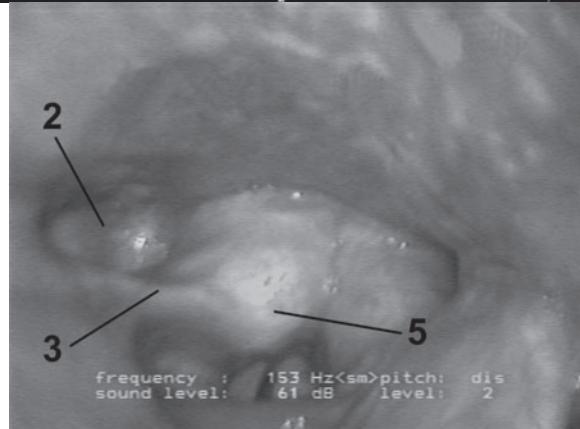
Deepening of the piriform recess (2), thickening and medialization of the aryepiglottic fold (3) and anterior positioning of the arytenoid cartilage (5) in CT and in larygovideostroboscopy.
